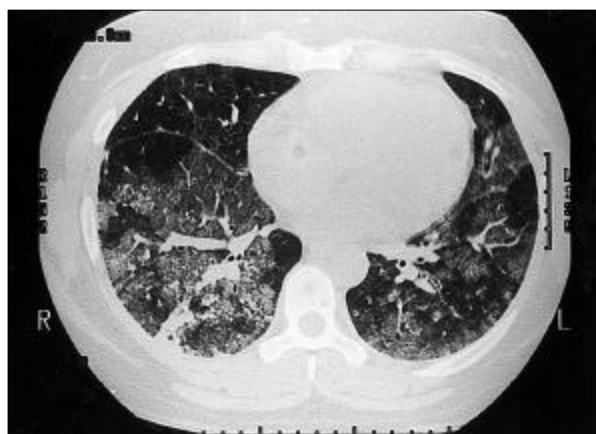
Diffuse, ground glass opacities of both lung fields on chest CT scan at the 1st day after first admission.
